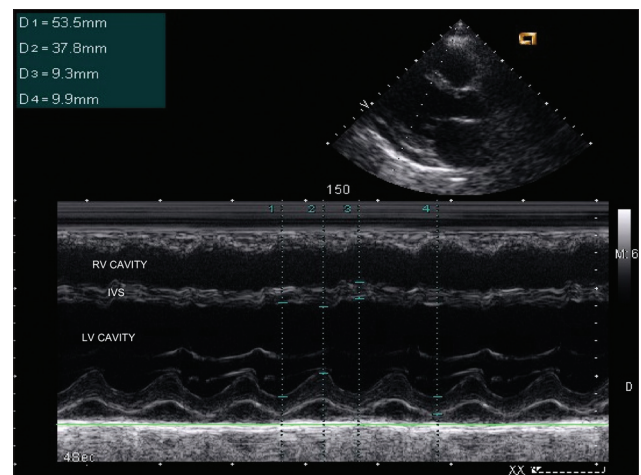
M-mode echocardiogram showing severely hypokinetic inter-ventricular septum. Right ventricle, left ventricle
